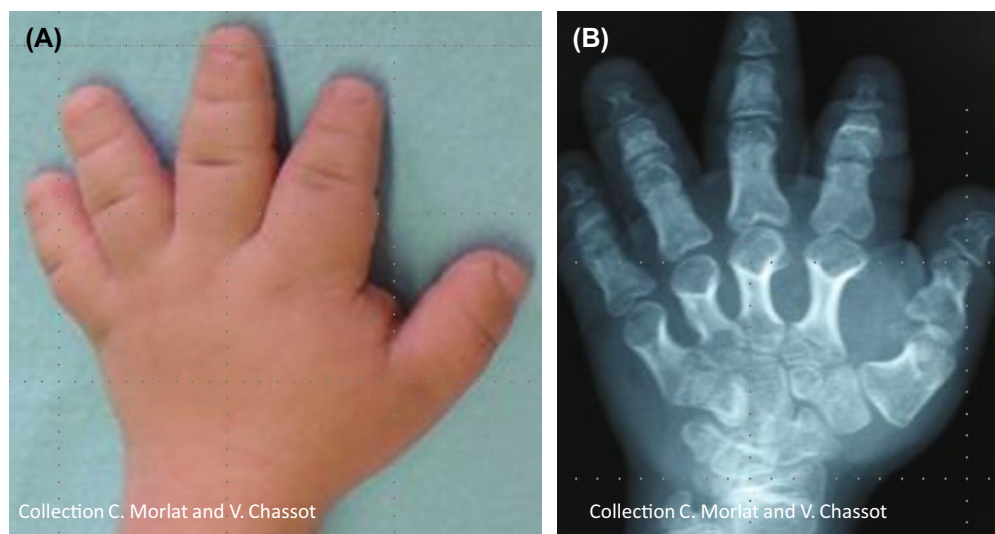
Picture (A) and X-ray (B) of one hand of a 13-year-old patient affected with ACRDYS1. The patient presents the shortening of metacarpals, metatarsals, and phalanges characterizing brachydactyly type E (BDE). Note the shortening of all bones and the bulky and stocky aspect of affected bones.
